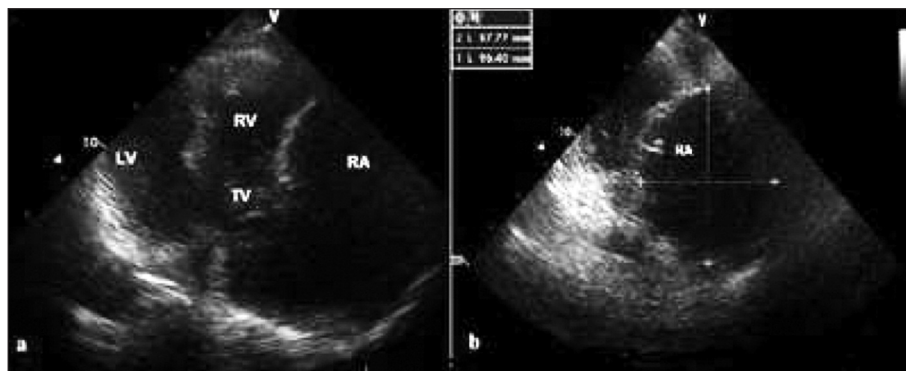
Transthoracic echocardiography from the apical four-chamber a) and modified b) view demonstrating an aneurysmal structure related to the right atrium. LA; Left atrium, LV; Left ventricle, RA; Right atrium, RV; Right ventricle, TV; Tricuspid valve, RAA; Right atrial aneurysm.
